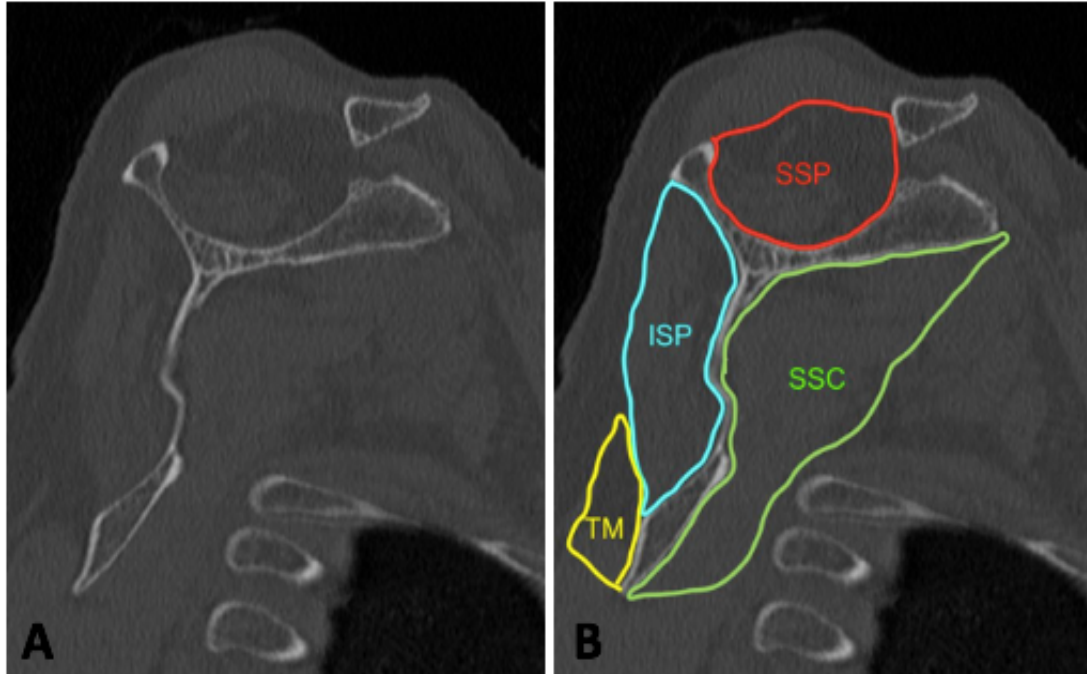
CT scan in sagittal oblique view ('Y-view') of a right shoulder. *This view allows for assessment of the degree of fatty infiltration of each of the four rotator cuff muscles. B: Anatomic location of SSP = supraspinatus, ISP = infraspinatus, TM = teres minor, SSC = subscapularis and dimensions in a normal, non-fatty infiltrated, state. (S. Abdic, 2018)*
